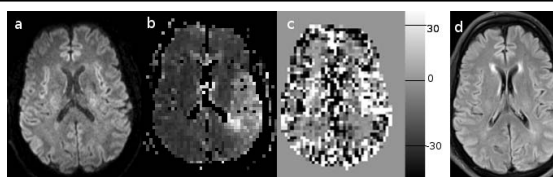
Images of an acute stroke patient. a. DWI b. MTT c. AUC of the loop (unit:  $\text{s}^{-5/2}$ ) on day 0 and d. FLAIR on day 6.
